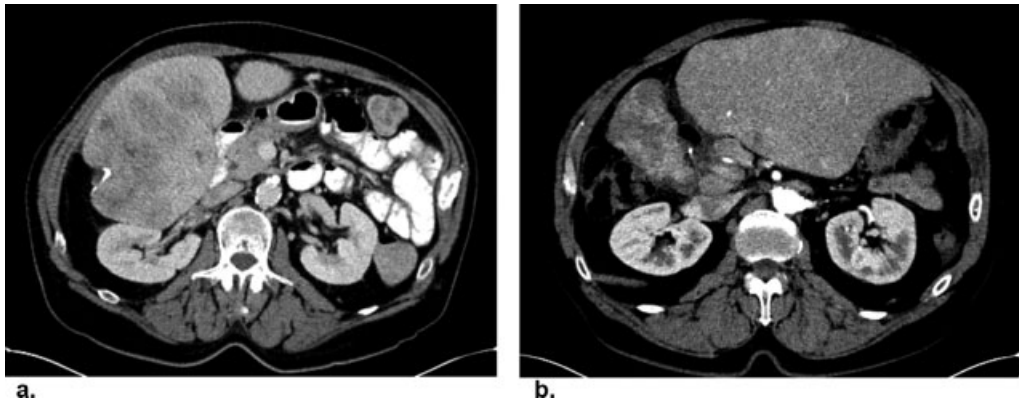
A 57-year-old patient with metastatic pancreatic neuroendocrine tumor causing significant abdominal pain and partial gastric outlet obstruction treated with transarterial radioembolization (TARE). Pre-TARE contrast-enhanced CT scan demonstrates a large inferior right hepatic lobe neuroendocrine tumor metastasis causing significant mass effect with abdominal bulge, compression of the duodenum, and right kidney (a). The patient's right hepatic lobe received two administrations of 1 day precalibration ^{90}Y resin microspheres 1 month apart with a total activity of 4.43 GBq. The patient's partial gastric outlet obstruction and abdominal pain started improving 1 month posttreatment and completely resolved 3 months later. A 2-year post-TARE contrast-enhanced CT scan demonstrates significant shrinkage of the right hepatic lobe and tumor with resolution of mass effect (b).
